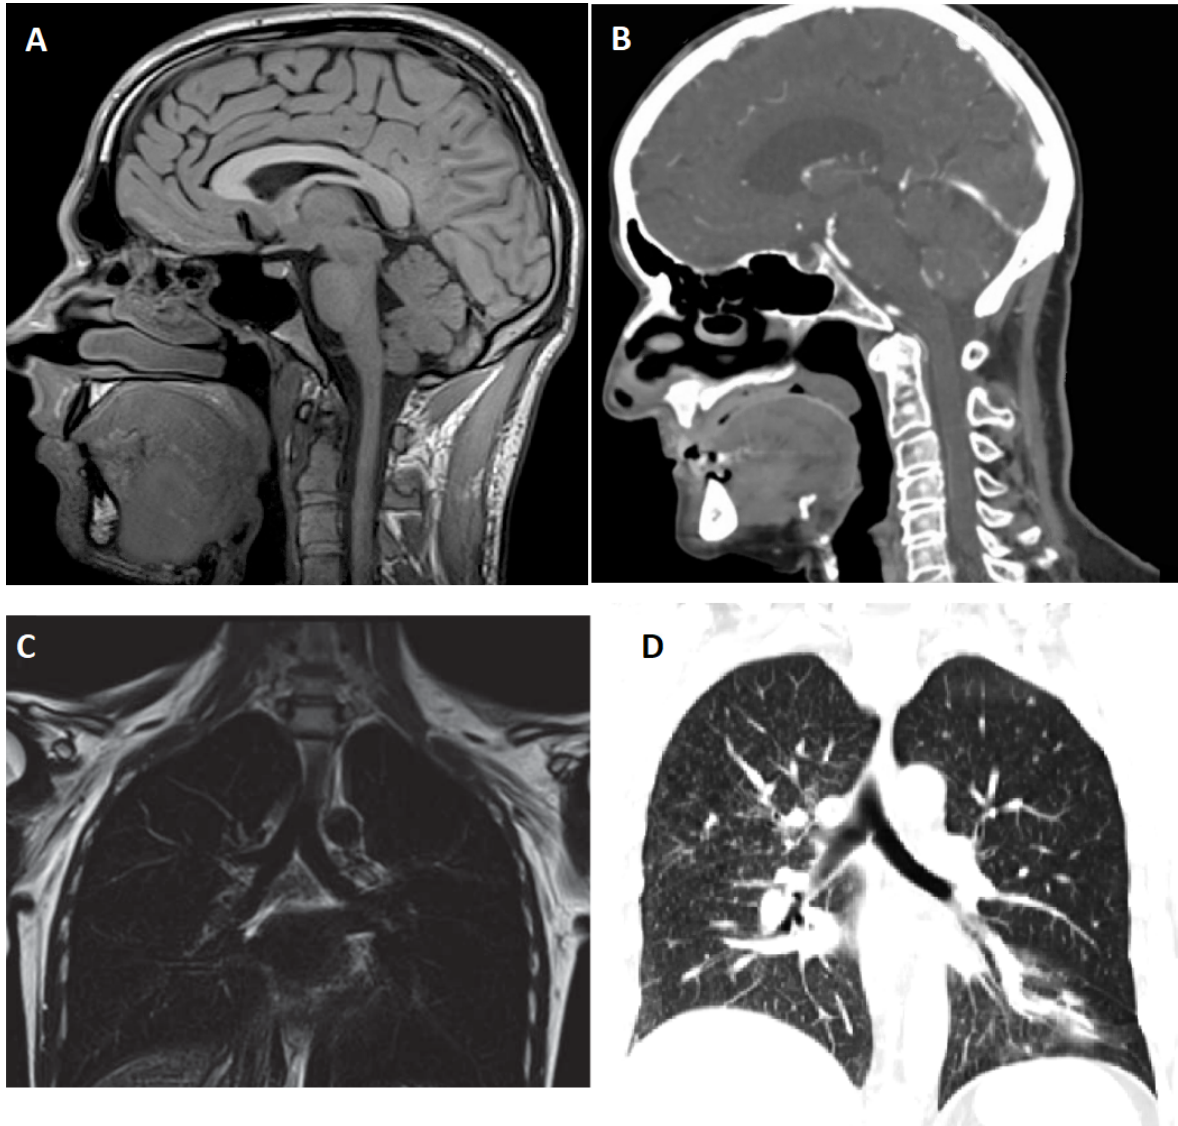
(A) T1 weighted MRI image of brain – all upper airways are clearly visible, (B) CT scan, brain scanning protocol – all upper airways are clearly visible with possibility of threshold segmentation, (C) T2 weighted MRI image of lungs – airway tree is visible only down to second branching generation, (D) CT scan of lungs with vascular contrast agent, lung scanning protocol – more generation of airway tree is visible than in part (C).
